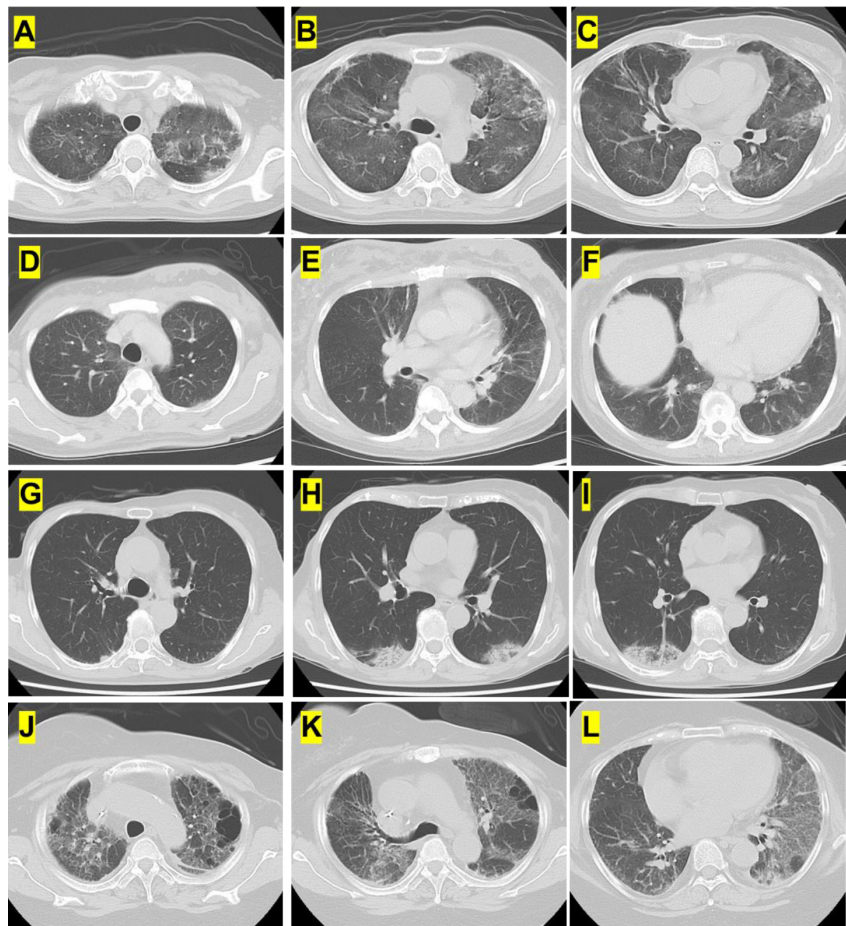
Computed tomography radiographs of the chest in four patients revealed evidence of drug-induced lung injury due to trastuzumab deruxtecan administration. Case 1 (A-C), Case 2 (D-F), Case 3 (G-I), and Case 4 (J-L).
